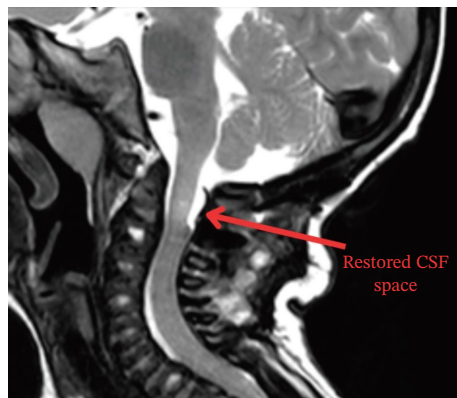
6-month postoperative sagittal T2-weighted magnetic resonance image demonstrating reduced signal intensity within the spinal cord and decompression at the level of C1–2, with restoration of the cerebrospinal fluid space surrounding the spinal cord (red arrow).
